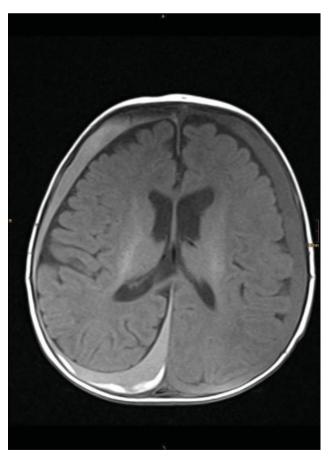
Typical MRI findings in shaken baby syndrome showing bilateral subarachnoidal bleedings of different ages extended into the interhemisphere gap. MRI, magnetic resonance imaging.
